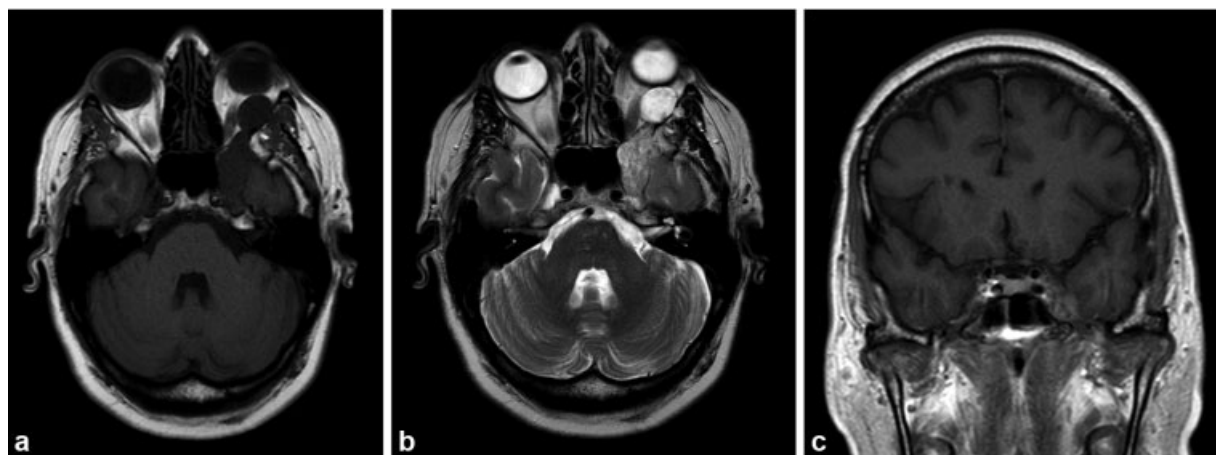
Preoperative images. (a) Axial T1-weighted gadolinium-enhanced image with a rounded aspect measuring 1.9 cm in its largest diameter, without impregnation by the gadolinium. (b) Axial T2-weighted image, showing a hyperintense lesion. (c) Coronal T1-weighted gadolinium-enhanced image.
